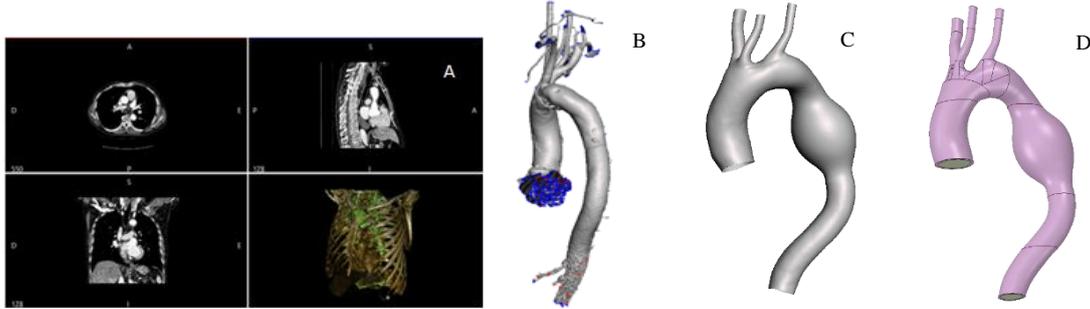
A- Computed tomography used in InVesalius; B- Image of the model to be worked on Meshmixer; C- Meshmixer final image; D- Ansys final image
